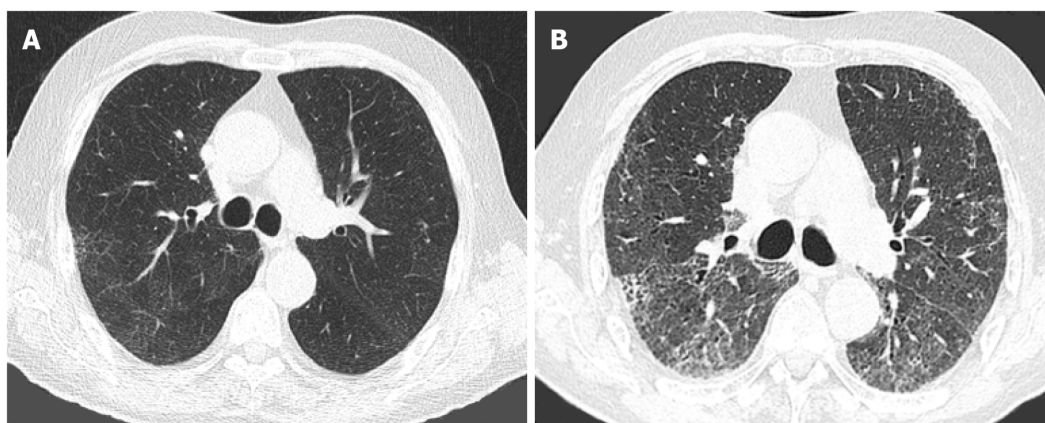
Pulmonary fibrosis. Axial images from computed tomographies of the chest performed 2 yr apart in an 83-yr-old male with a history of silicosis. A: In June 2018, there was mild lung hyperaeration with mild reticulation; B: In August 2020, 4 mo after recovering from coronavirus disease 2019 pneumonia, there is extensive fibrosis, with areas of honeycombing, traction bronchiectasis/bronchiolectasis and architectural distortion.
